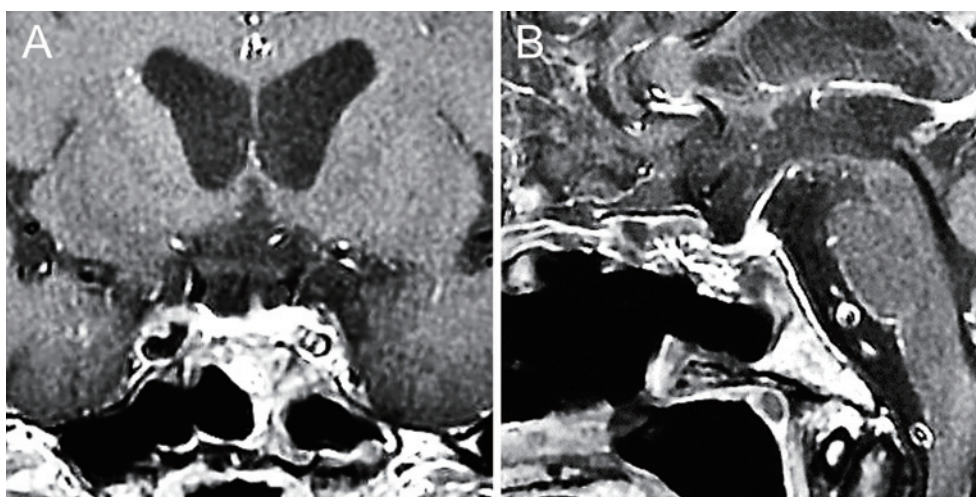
Postoperative coronal (A) and sagittal (B) contrast-enhanced T1-weighted magnetic resonance images showing total resection of the pituitary tumor and skull base reconstructed with autologous tissues.
